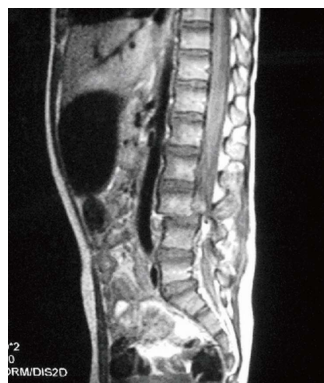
Initial magnetic resonance imaging, sagittal view T1-weighted, showing Chance fracture with dislocation of the 3<sup>rd</sup> lumbar vertebra and neurological compression.
